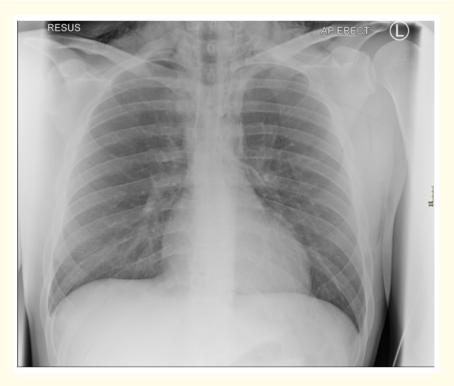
AP erect chest radiograph demonstrates linear and curvilinear lucencies outlining the left heart border and mediastinum consistent with pneumopericardium and pneumomediastinum, respectively. Further assessment also shows a tiny subcentimetre left apical pneumothorax with extensive subcutaneous emphysema in the supraclavicular fossae bilaterally. The background lung appears grossly unremarkable. No radiopaque foreign bodies or acute osseous injury.
